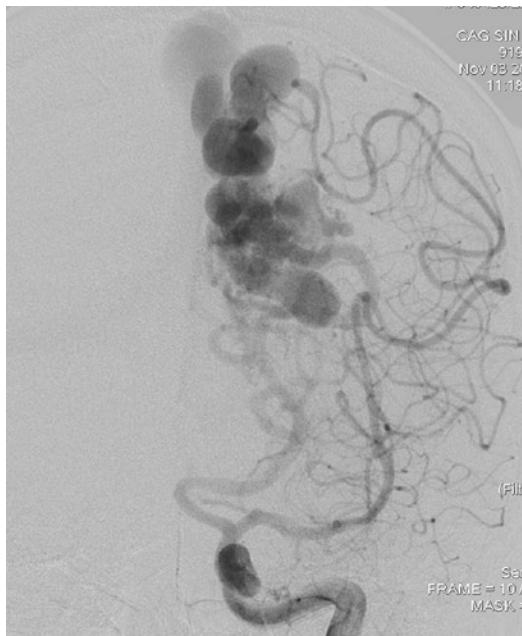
Catheter angiogram (A-P view) of right frontal AVM SM I with superficial draining veinFig. 7.3 T2-weighted axial MR scan of left occipital AVM SM II
